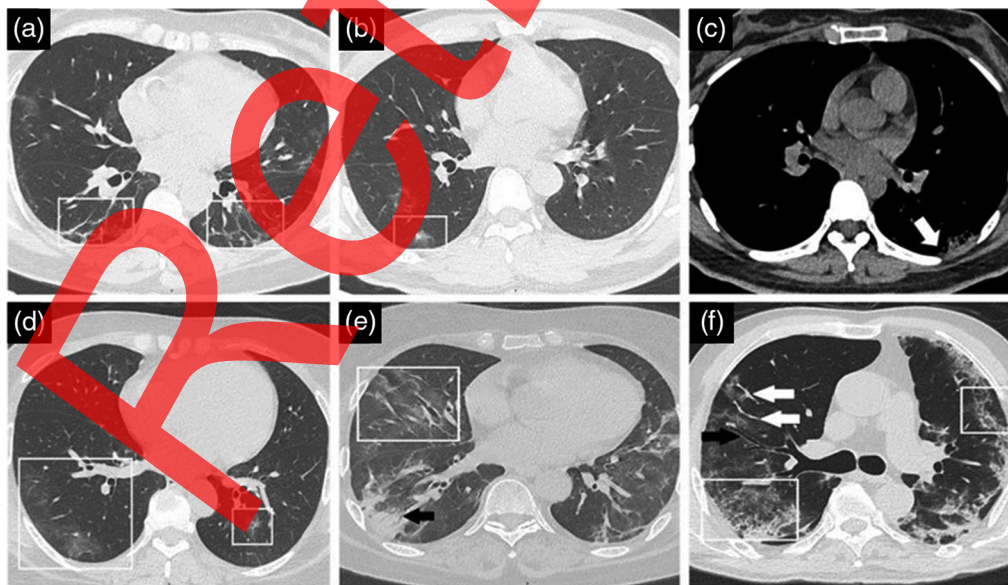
Lung CT images of COVID-19 patients: (a) a 56-year-old woman, (b) a 37-year-old man, (c) a 32-year-old, (d) a 50-year-old woman, (e) a 59-year-old woman, and (f) a 65-year-old man.
